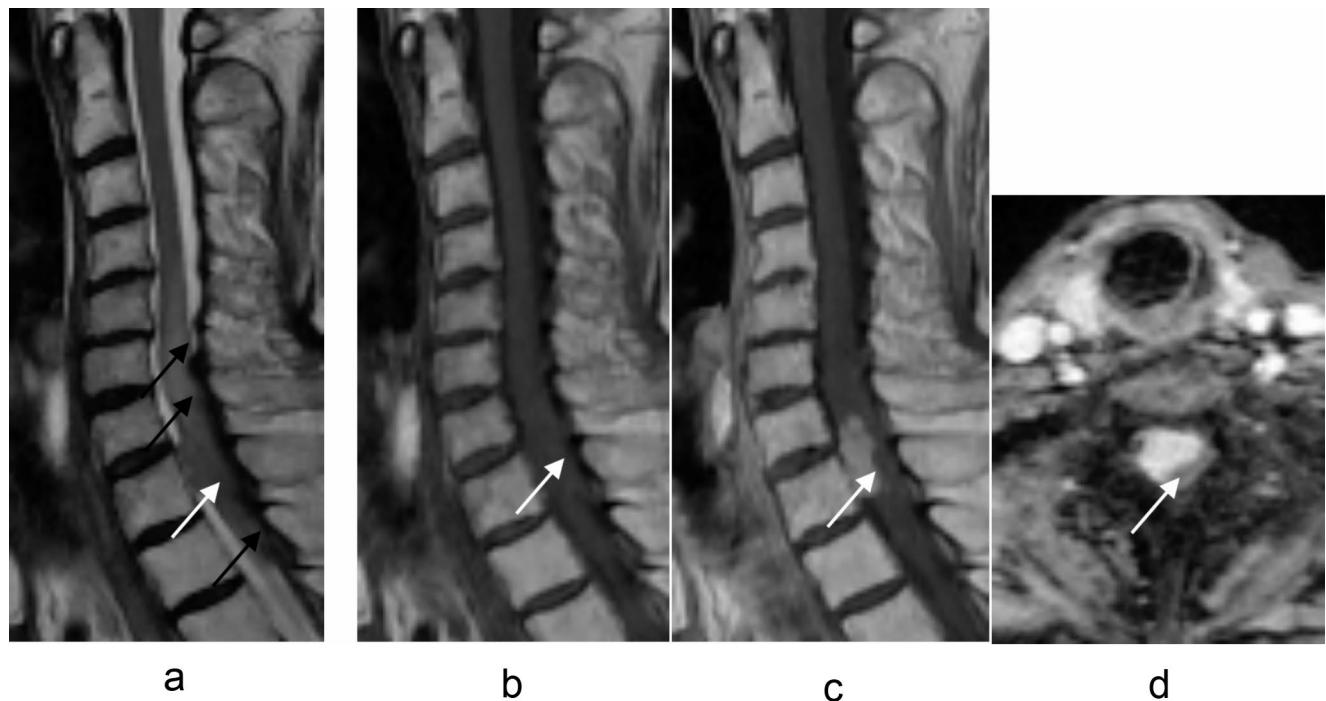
(a-d) Preoperative MR images (a) T2-weighted image, (b) T1-weighted image, and (c, d) contrast-enhanced MRI. (d) Axial image at the C7/Th1 level. Contrast-enhanced MRI revealed an intradural extramedullary lesion with homogeneous internal enhancement
